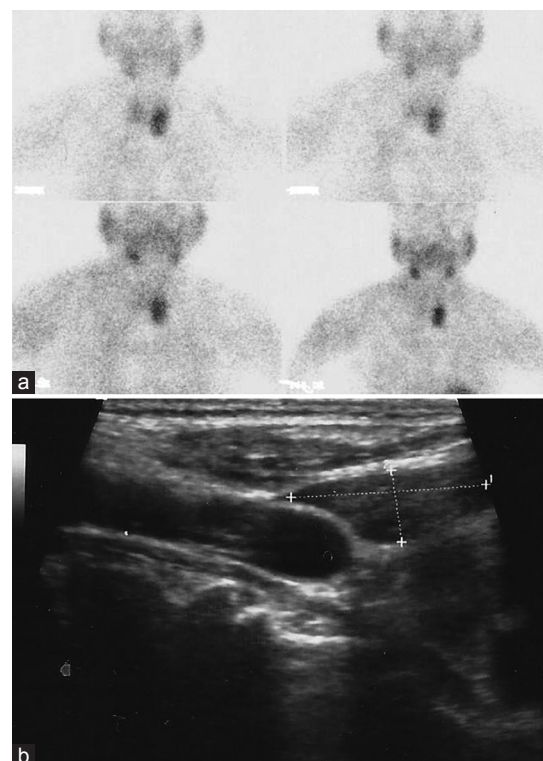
The left inferoposterior parathyroid adenoma detected by scintigraphic (a) and ultrasonographic (b) images
